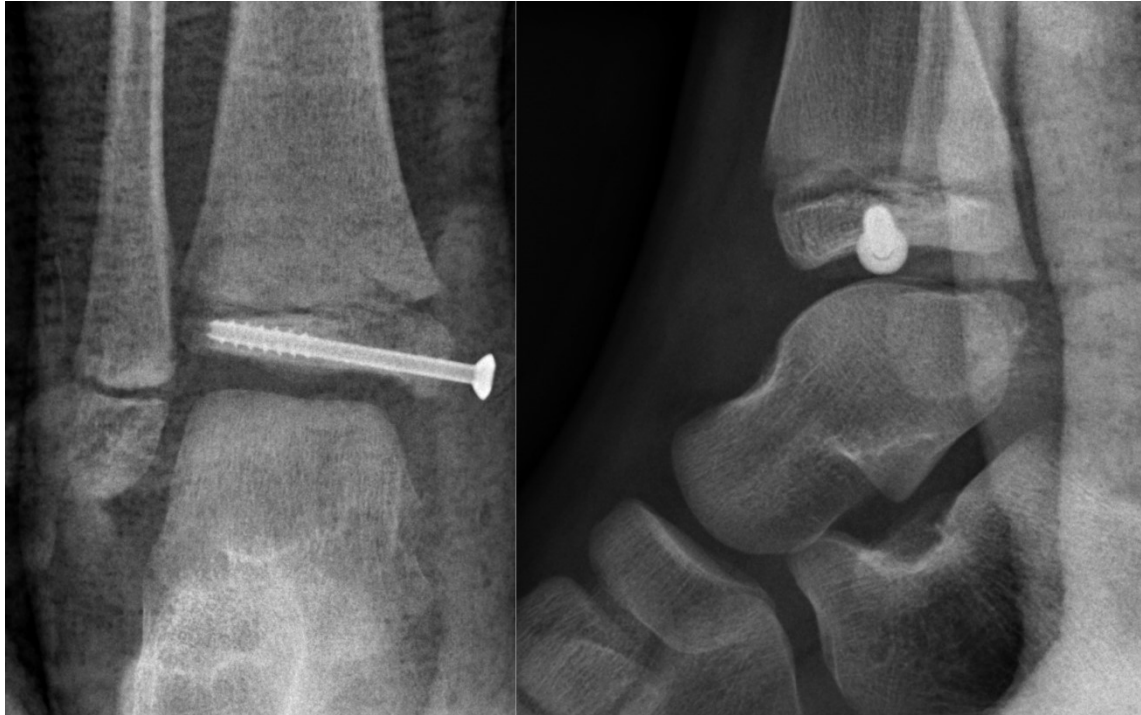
Postoperative a.p. and lateral radiograph of a right ankle joint with a Salter Harris III fracture of a 7-year-old boy
